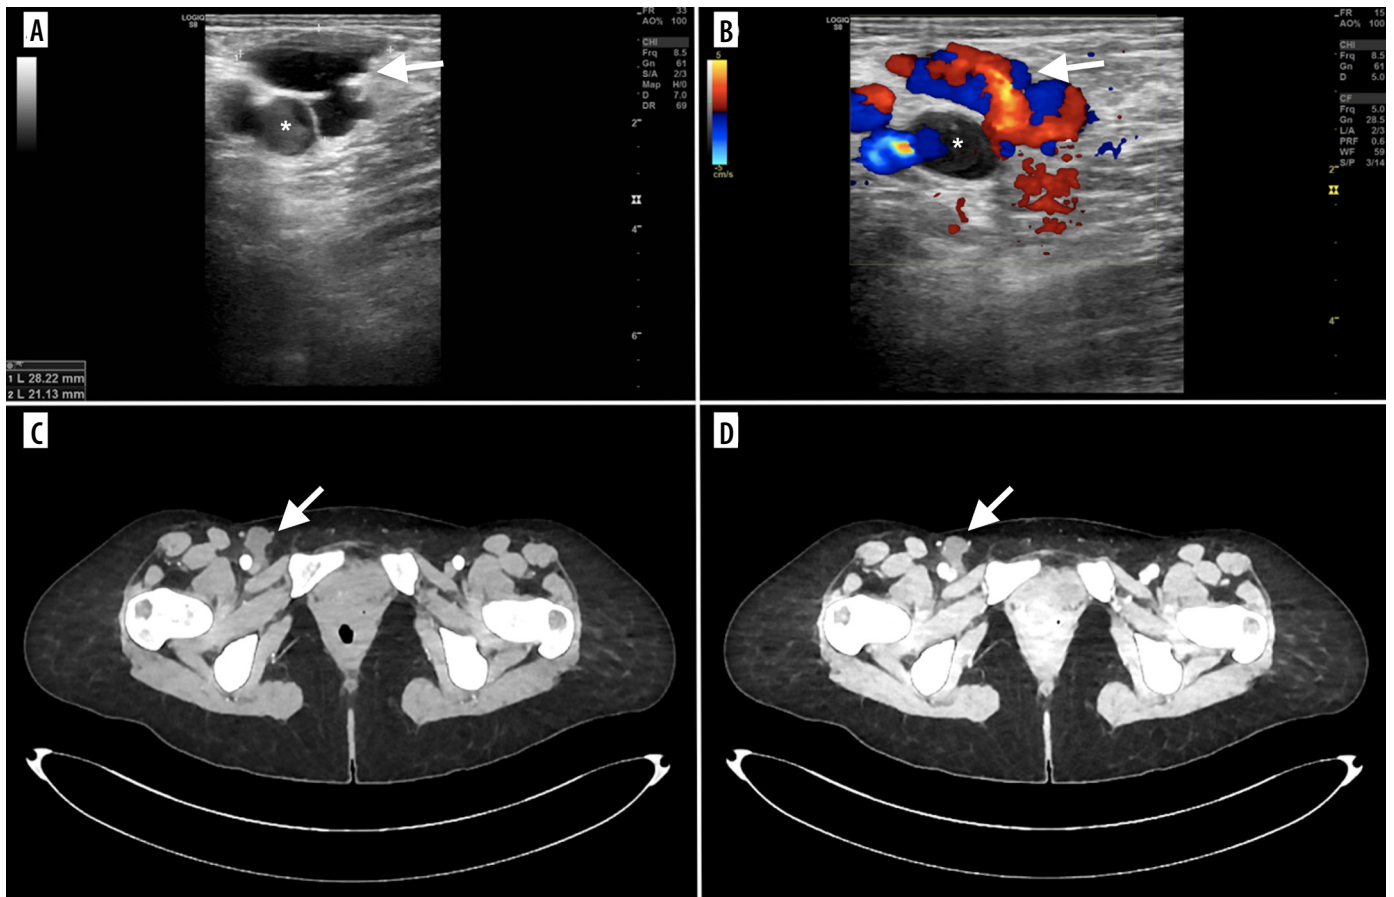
Imaging findings of a lymphatic malformation adjacent to the right common femoral vein. A) Grayscale ultrasound reveals a well-circumscribed, anechoic cystic lesion. B) Color Doppler ultrasound during the Valsalva maneuver demonstrates an artifactual "yin-yang" sign within the cyst, mimicking a pseudoaneurysm. C, D) Axial contrast-enhanced computed tomography images in the (C) arterial and (D) venous phases confirm the non-enhancing cystic nature of the lesion. The arrow indicates the lymphatic malformation. The asterisk (*) denotes the common femoral vein
